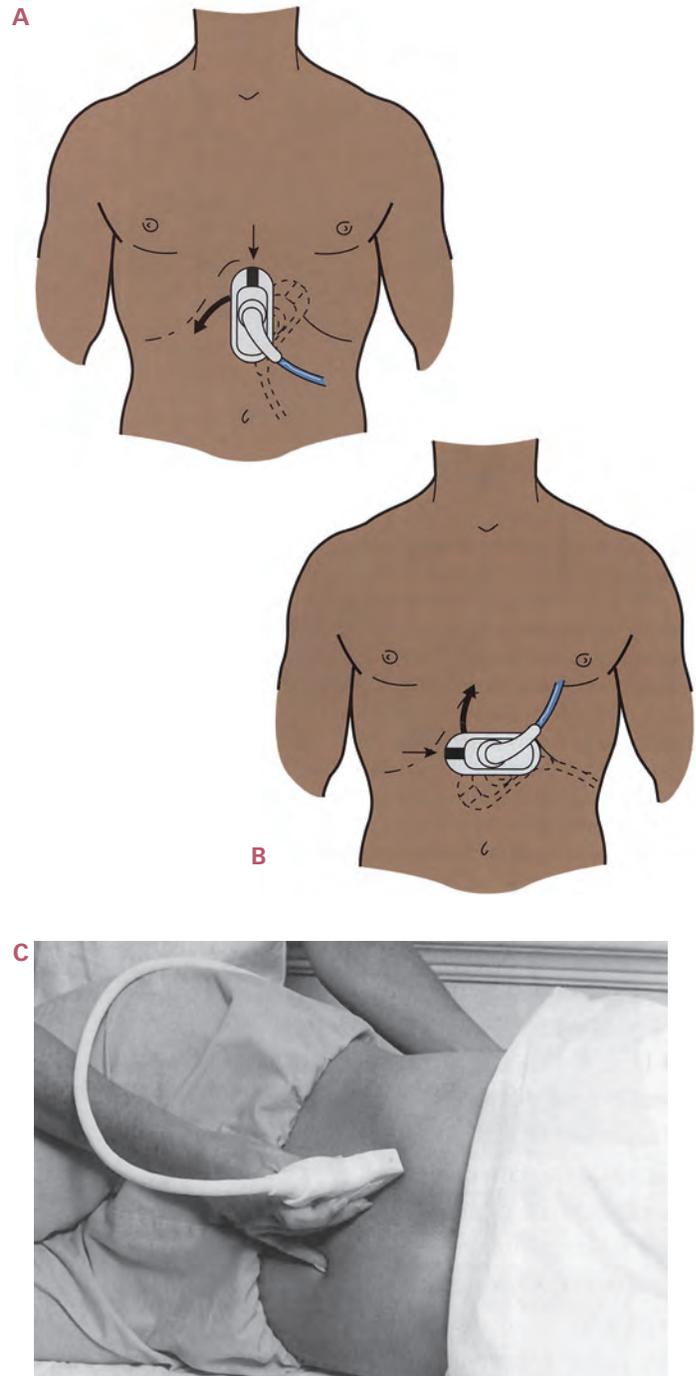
A, B Rotating the transducer. C Image of a patient in the left lateral decubitus position with the transducer rotated counterclockwise from the longitudinal into the right costal margin. Reprinted with permission from Gill KA: Abdominal Ultrasound: A Practitioner's Guide. Philadelphia, Saunders, 2001.
